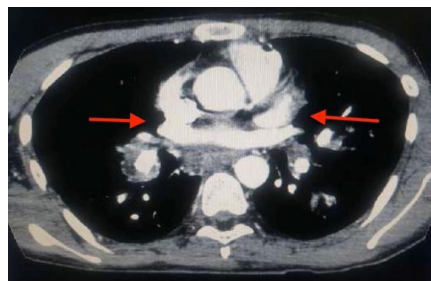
Chest CT with contrast revealing thrombosed aneurysm of the inferior lobar artery bilaterally with an obstructive intraluminal thrombus of a segmental branch of the right superior lobe.
